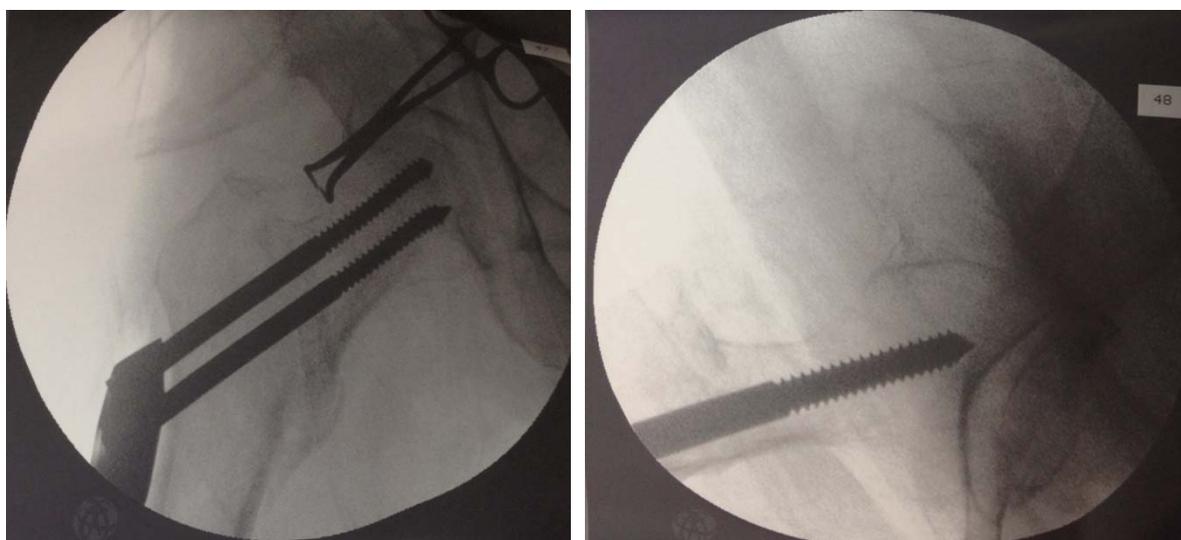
Correct position of lag-screws selfdynamisable internal fixator implant in anterior-posterior and profile radiographic imaging to avoid cut-out complications.
